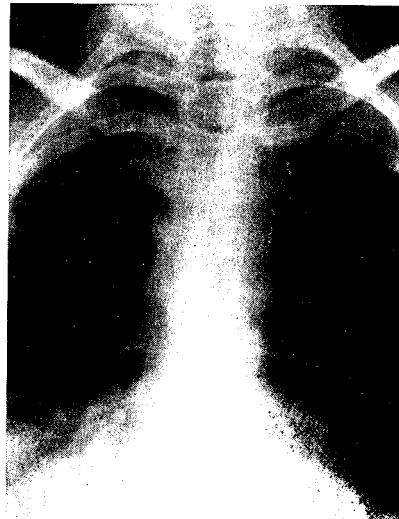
The PA radiogram of the patient after the X-ray therapy.
